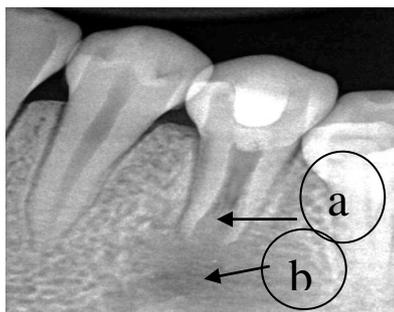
6-month post-operative view of 35 indicating little radiopacity in relation to root apex reporting hard tissue generation(a) and partial resolution of the periapical lesion in relation to the tooth (b).
